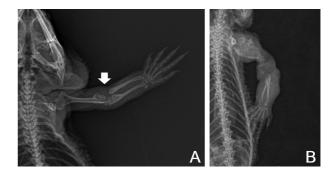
Radiographs. (A) Before humeral lysis, the first radiograph shows a distal epiphysis lytic lesion (white arrow) in the left humerus. (B) After humeral lysis. Expansile signs and multifocal destruction are observed.
